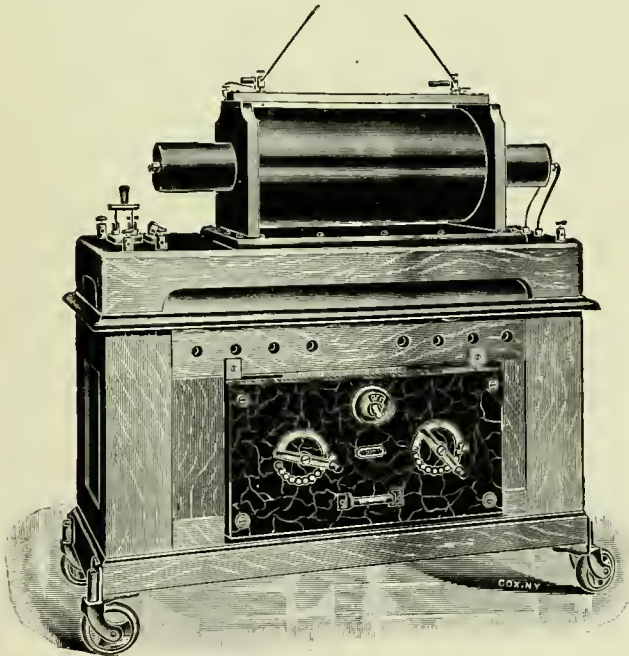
Type of X-Ray Coil.
